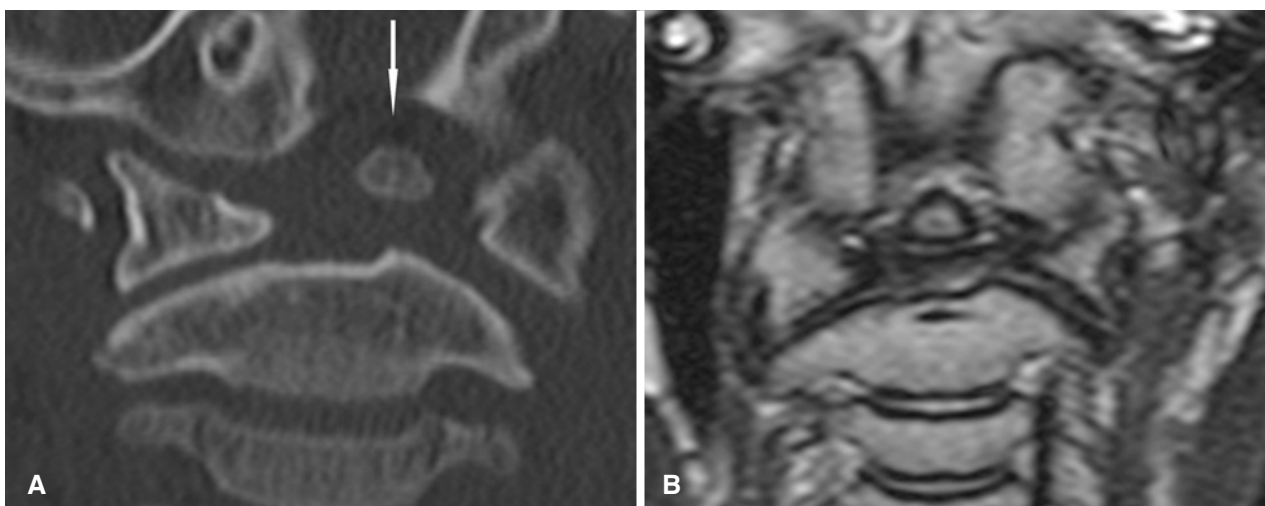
Instability of the os odontoideum: A Dislocation of the os odontoideum to the left side during a rotation of the head (arrow), B Coronal T1-weighted image demonstrated a central position of the os odontoideum.
